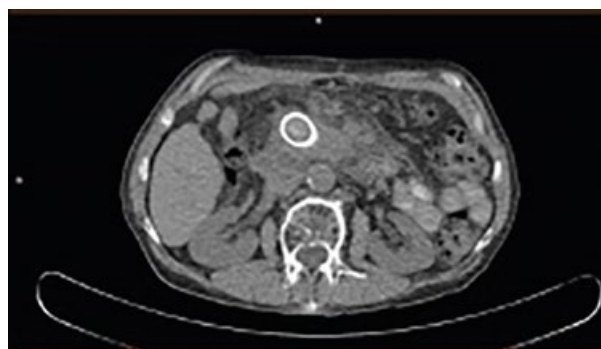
PET-CT with 18F-FDG without contrast enhancement, control 14 days after the end of CT. The formation in the head of the pancreas persists with a marked decrease in metabolism and metabolic volume, SUVmax=3.98, metabolic volume 2.75 cm³.
